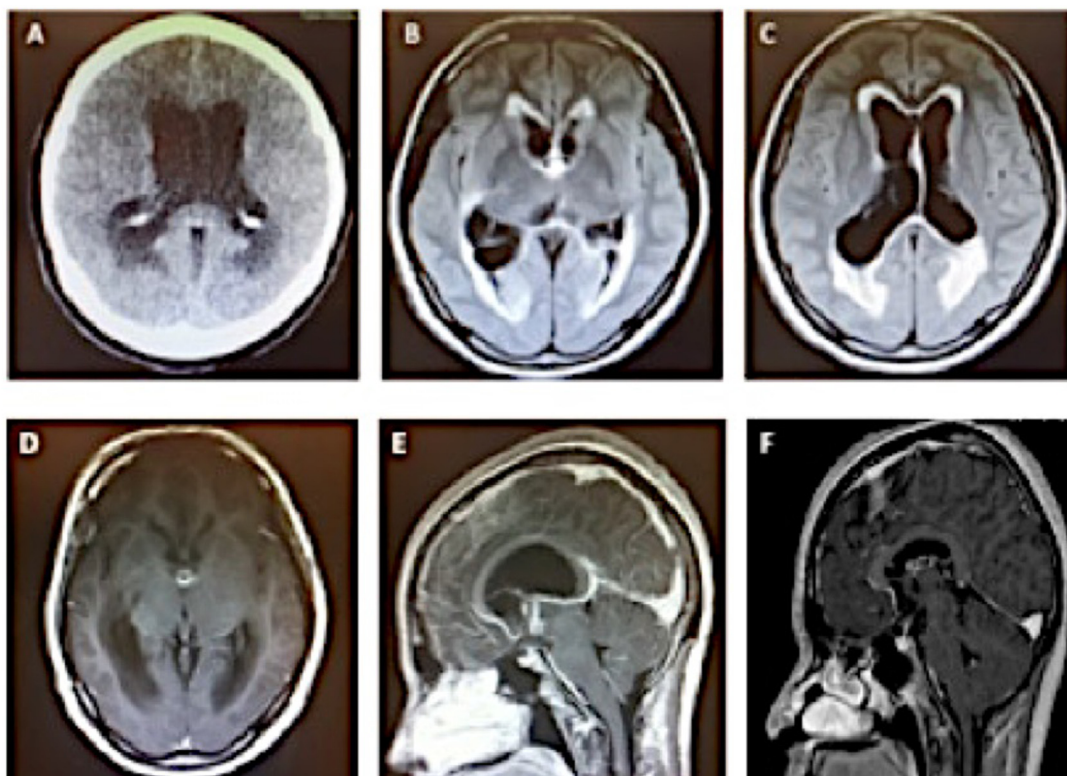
(A) Axial CT, showing dilation of the lateral ventricles. (B, C) Axial MRI FLAIR sequences, showing hyperintense rim surrounding the ventricles, corresponding to ventriculitis. D,E. Axial T1 post-contrast (D) and sagittal T1 post-contrast (E) sequences, showing the same nodular lesion (arrow), preoperatively. (F) Sagittal T-1 post-contrast, postoperatively.
